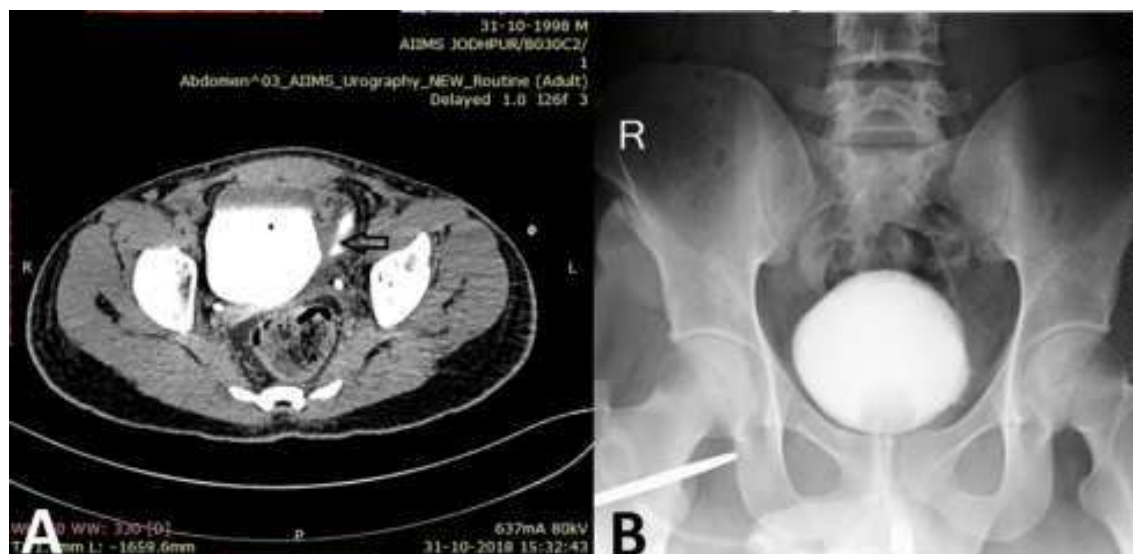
CT urogram image depicting leakage of contrast through a defect in anterior wall of bladder on left side suggestive of intraperitoneal bladder injury (arrow). B: Cystogram image in follow-up showing no leakage of contrast.
